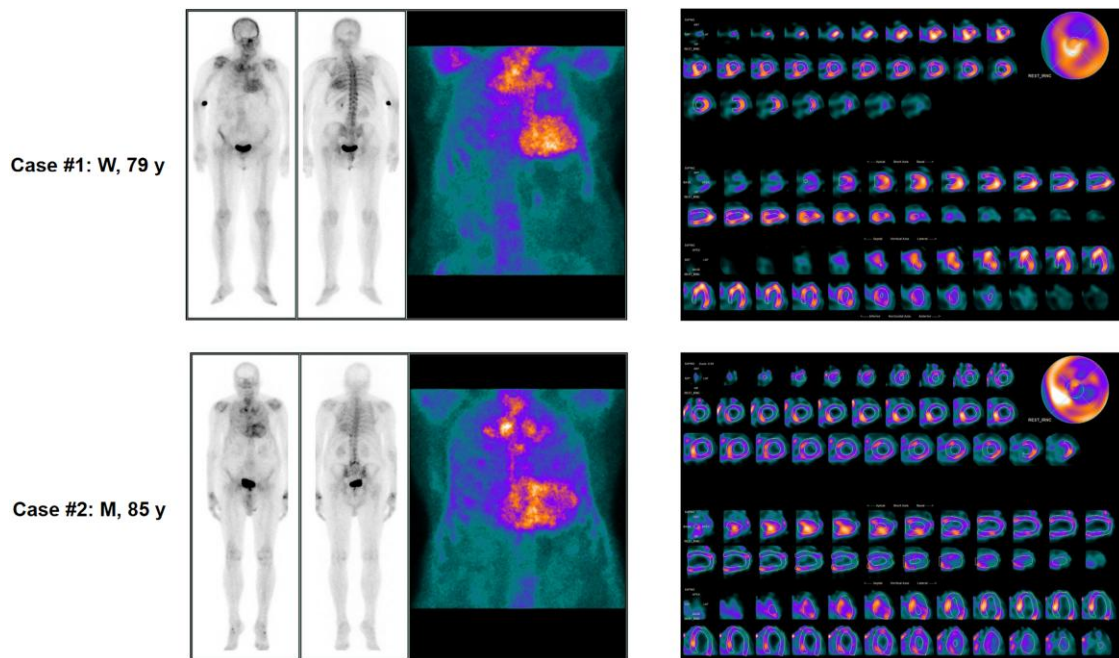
Scintigraphy findings in two patients diagnosed with wild-type transthyretin cardiac amyloidosis and Grade 3 uptake. Findings from a woman and a man receiving a non-invasive diagnosis of transthyretin cardiac amyloidosis are provided. See text for further details. Left: planar scintigraphy. Right: single-photon emission computed tomography. M, man; W, woman.
